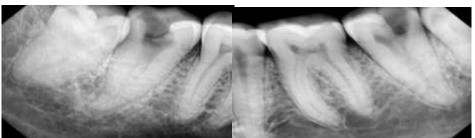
Preoperative IOPA radiograph#47 and#37
